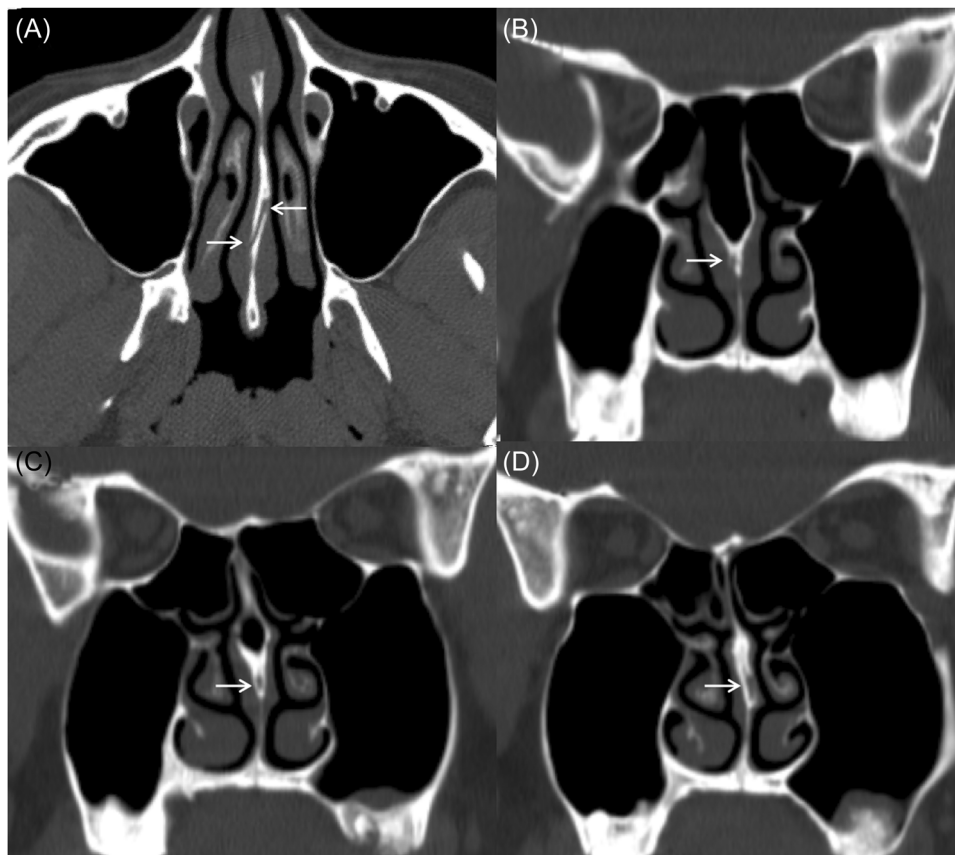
CT shows the anatomical variation of the PSA. The right PSA passed through a bony canal in the posterior of the nasal septum to the left side (the white arrows indicated in A). The arrow in (A–D) indicates the PSA traveling process. The exit point of PSA at the left side of the nasal septum is located behind the nasal septal spur (D). CT, computed tomography; PSA, posterior septal artery.
